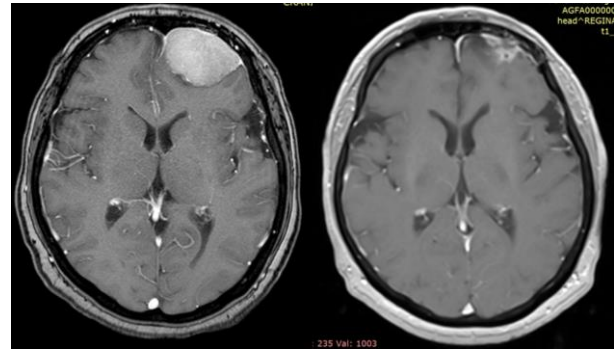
Preoperative and postoperative axial T1-weighted images with contrast of an atypical meningioma (Professor Poeata's personal collection)
